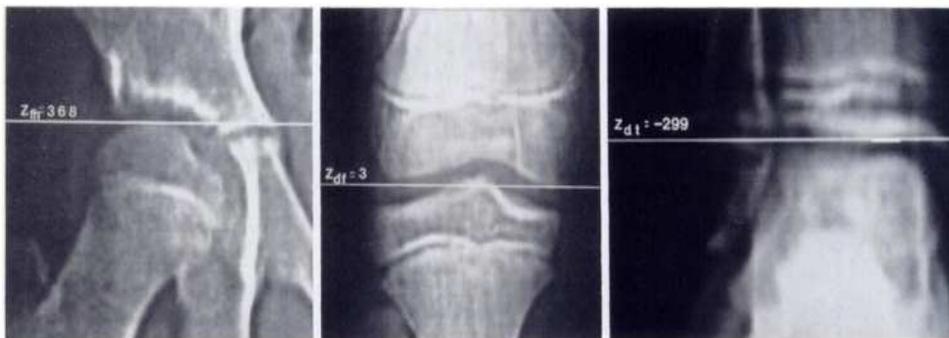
CT scout measurements, recommended by Aitken *et al.*
